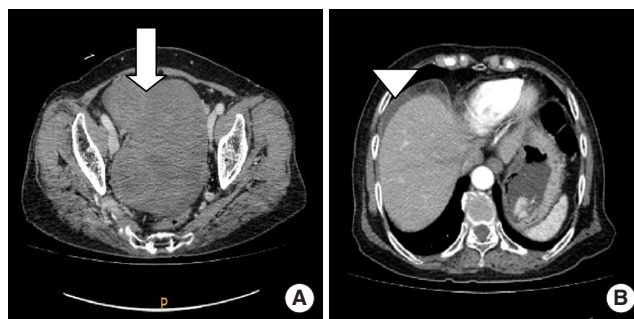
(A, B) The contrast-enhanced abdomen and pelvic computed tomography scan showed solid large pelvic mass (arrow) and ascites (arrow head).
